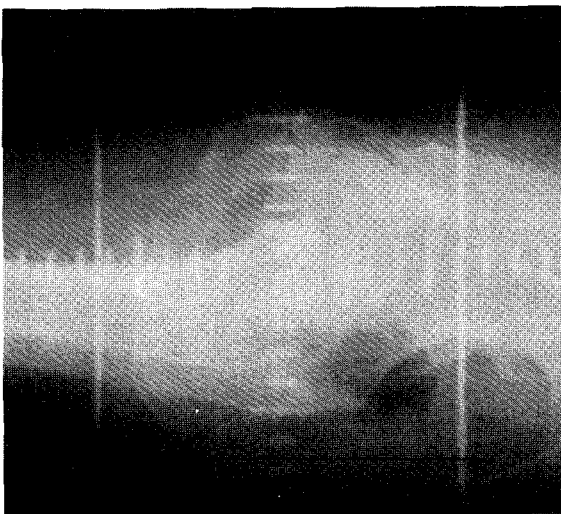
Lateral radiograph showing treatment volume. Note the mercury filled Foley catheter which denotes the position of the prostatic urethra.
